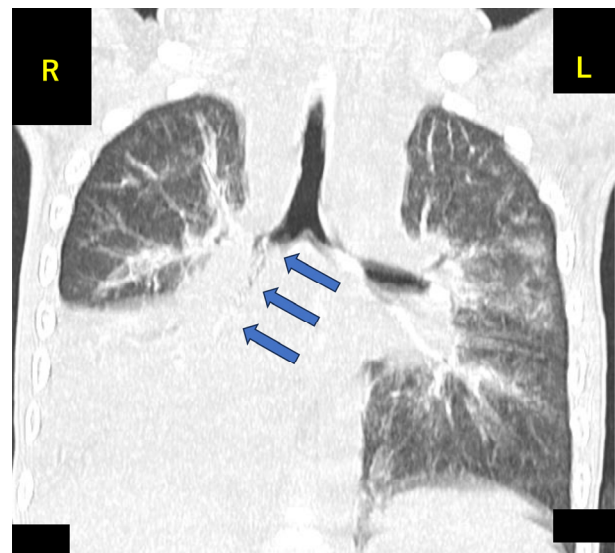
CT image demonstrating PB that developed at age 4. An intraluminal soft-tissue density lesion suggestive of a mucus plug extended from the right main bronchus to the right lower lobe bronchus (blue arrow). L, left; R, right.
